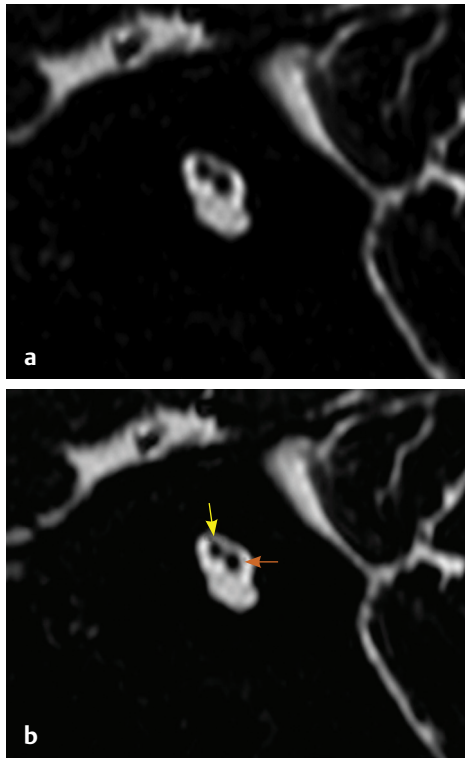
(a) MRI CISS/FIESTA sequence, oblique sagittal images at fundus of internal acoustic canal and (b) show vestibulocochlear nerve (brown arrow) and facial nerve (yellow arrow).
